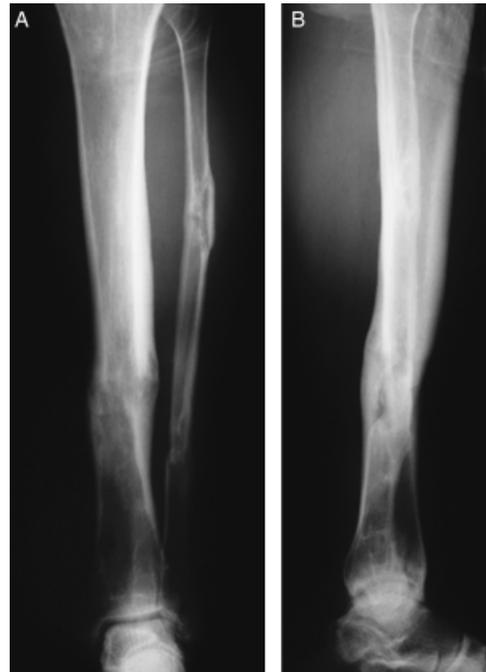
(A, B): Five years follow-up: x-rays of the left tibia without signs of osteomyelitis.
